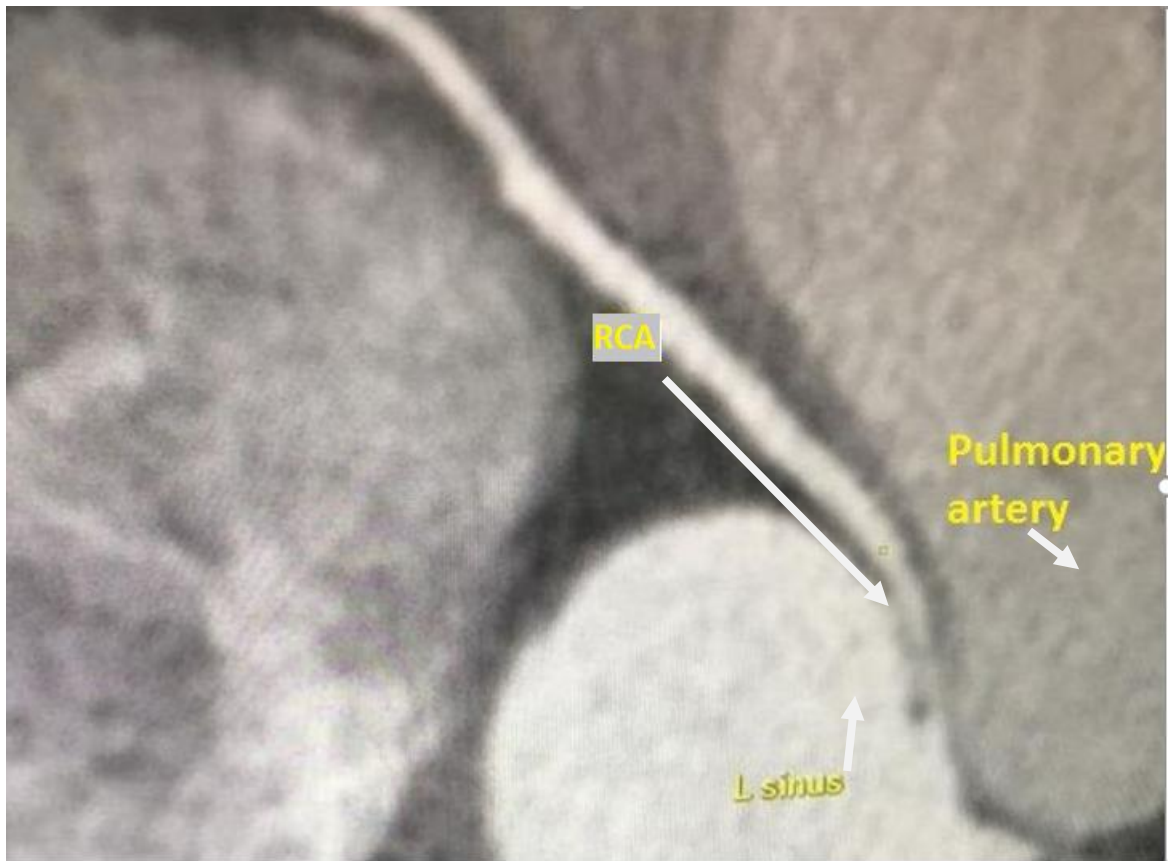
Cross section of coronary CT scan showing the right coronary artery (RCA) connected to the left coronary sinus (L.Sinus), coursing between the aortic root and pulmonary artery with a narrowed proximal segment
